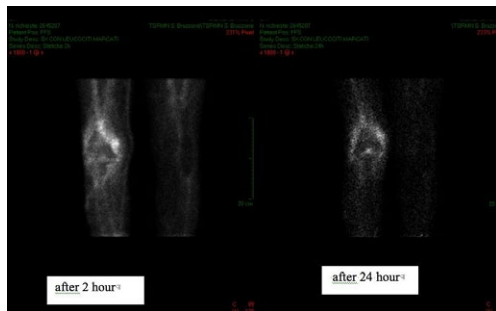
WBC scintigraphy in knee prosthetic joint infection. Persistent uptake in imaging at 24 h after injection.
